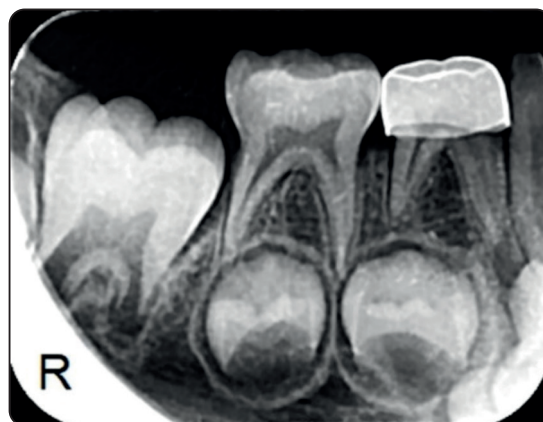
Post operative x-ray for class II in tooth no 85
